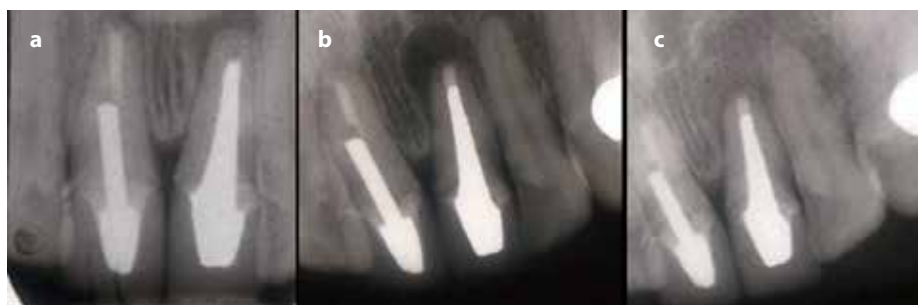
(a) UL1 with long post-retained crown with periradicular lesion. (b) Periradicular surgery for UL1 with MTA root-end filling: immediate post-operative radiograph. (c) 18 month post-operative review radiograph showing healed lesion.
